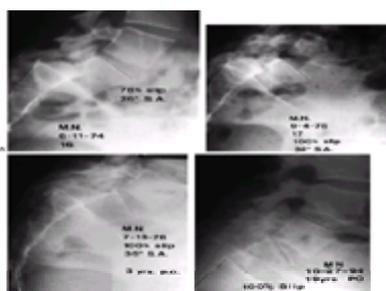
A: A patient was seen at the age of 16 years with low back pain and sciatica. A: The spot lateral lumbosacral radiograph showed a 78% displacement and a slip angle of 26 degrees. The patient was treated with decompression and L4-to-S1 posterolateral fusion, and after operation was ambulatory in a brace. B: Two months later, a standing radiograph in the brace showed an increase in the displacement to 100% and a slight increase in the slip angle to 32 degrees. C: Three years after operation the fusion was solid, the patient was free of pain, and the lumbosacral relation was unchanged. D: Nineteen years after operation the patient
